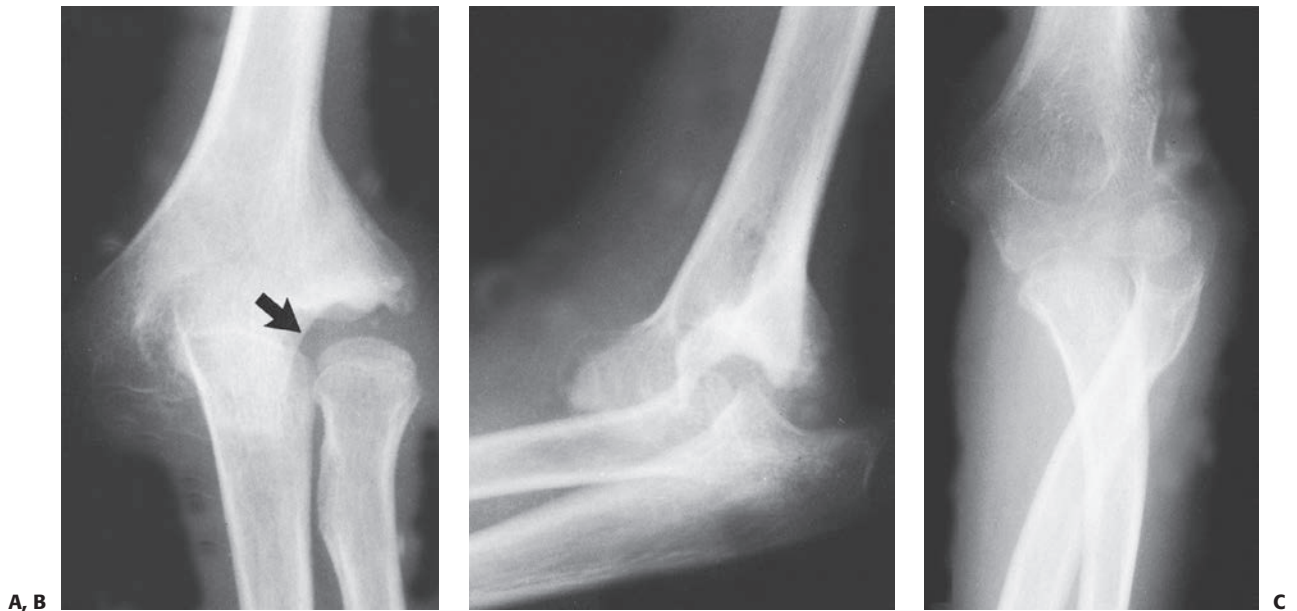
Unreduced dislocation. A: Preoperative anteroposterior radiograph. The elbow sustained an injury 3 years before surgery. Elbow motion was extremely limited and painful. The lateral supracondylar ridge had been eroded by the radial head (*arrow*). B: Lateral radiograph. The posterior position of the olecranon is apparent. C: Anteroposterior radiograph 3 months postoperatively. Total elbow motion was 30 degrees, but there was less pain and more stability.
